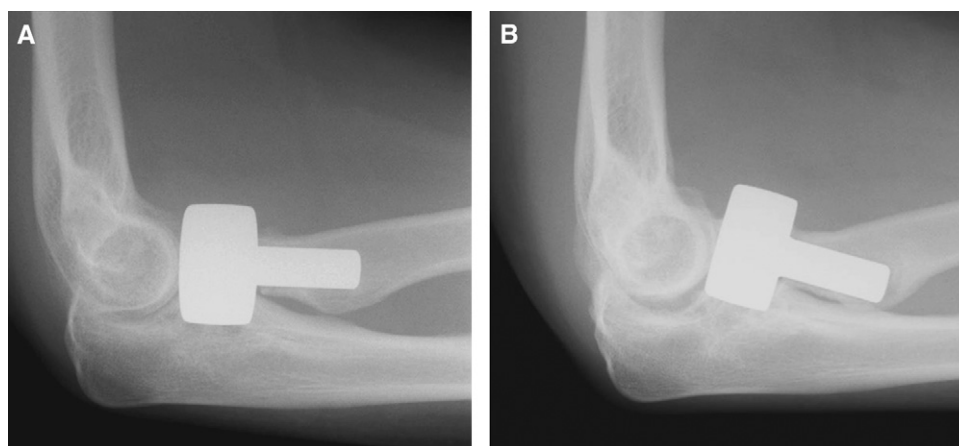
Forearm pain can also be seen with a smooth polished stem, as observed on these radiographs of a 24-year-old woman with progressive loosening and instability of the prosthesis within the canal. (A) Early postoperative radiograph showing a well-aligned uncemented Evolve prosthesis. (B) Radiograph taken 33 months postoperatively showing lucency and tilting of the prosthesis.
